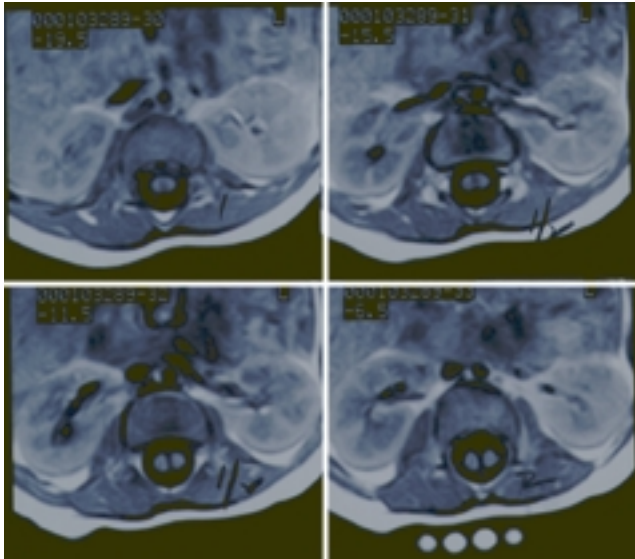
Axial MR images revealing a split spinal cord (diastematomyelia). The images are displayed in a cranial-to-caudal direction, left to right and top to bottom.
